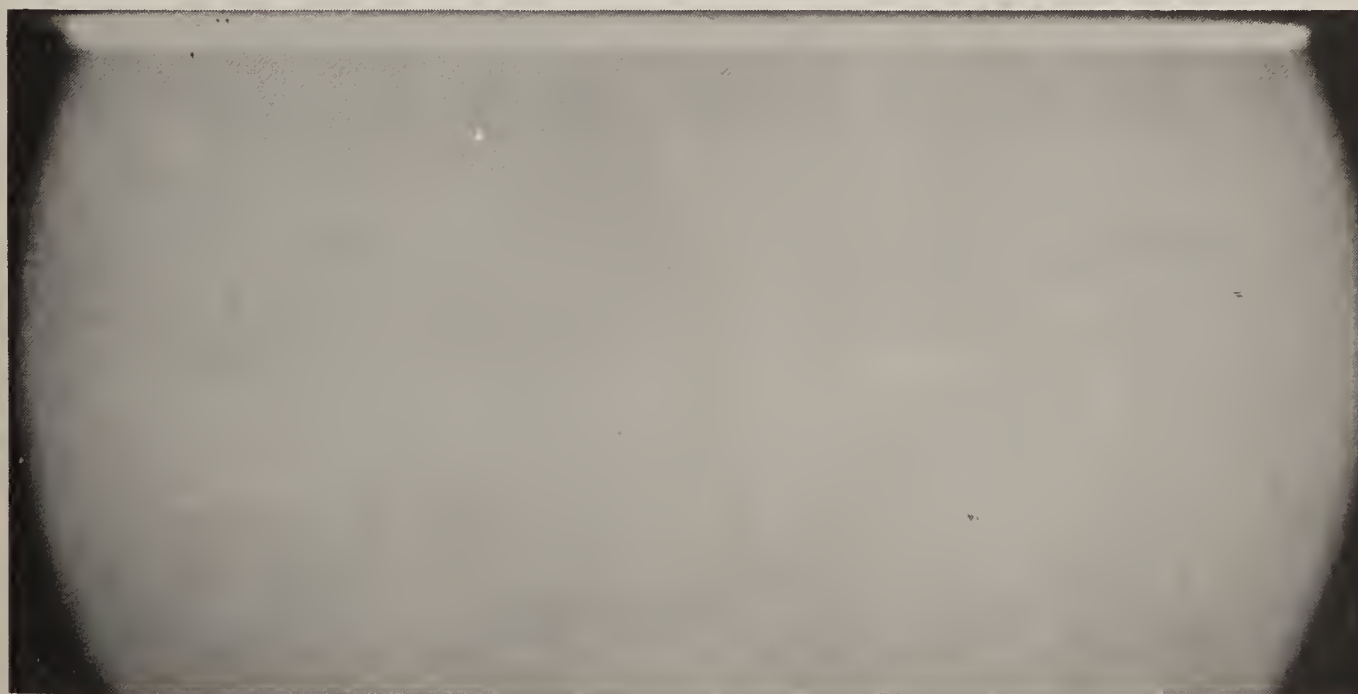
X-radiograph of the hemisphere in a plastic water box. The conditions were 126 cm focus to film, Du Pont high-speed 1A screen, Polaroid TLX film in Polaroid cassette, 30 KV peak, 200 MA, 3.0 seconds.
